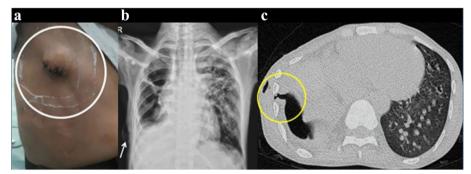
a A soft reducible mass, prominent on coughing, valselva noted at the site of previous intercostals drainage with overlying sutures. b Chest radiograph (A-P) view showing the presence of a tongue of herniated lung tissue at the right base overlying the herniated tissue. c CT chest showing the cicatricial collapse of the right lung, tractional bronchiectatic changes in the left lung with cavities in bilateral lungs, and presence of aspergilloma in the left apical region with features of pulmonary arterial hypertension. Pleural dehiscence with lung herniation is seen in the right lung
